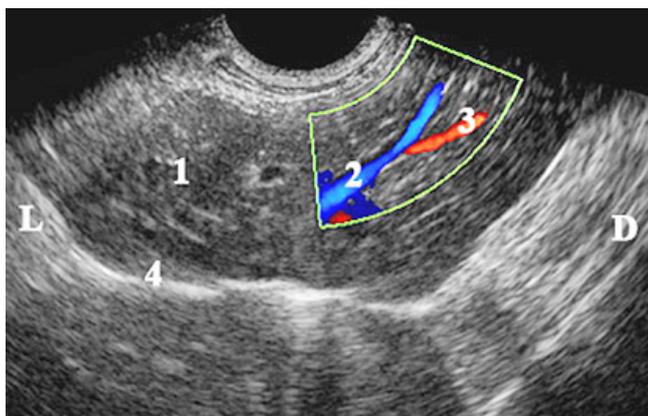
Color Doppler US image of hepatic veins and portal vein (color and pulse Doppler transducer – 7.5 MHz). L – left; D – right. (1) left lobe of the liver; (2) hepatic veins; (3) portal vein; (4) fibrous capsule and diaphragm
